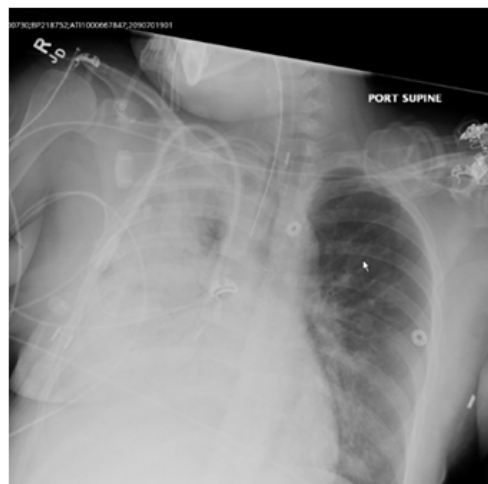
Bedside X-ray demonstrating worsening appearance of the chest with multiple areas of consolidation in the right lung, possibly multilobar pneumonia.
